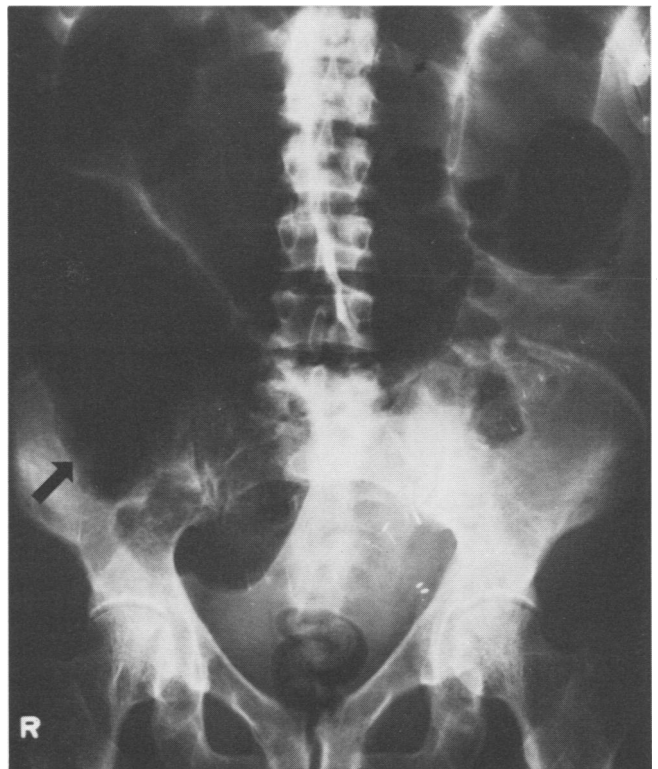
Abdominal roentgenogram demonstrating massive cecal dilatation (arrows) prior to colonoscopy.
